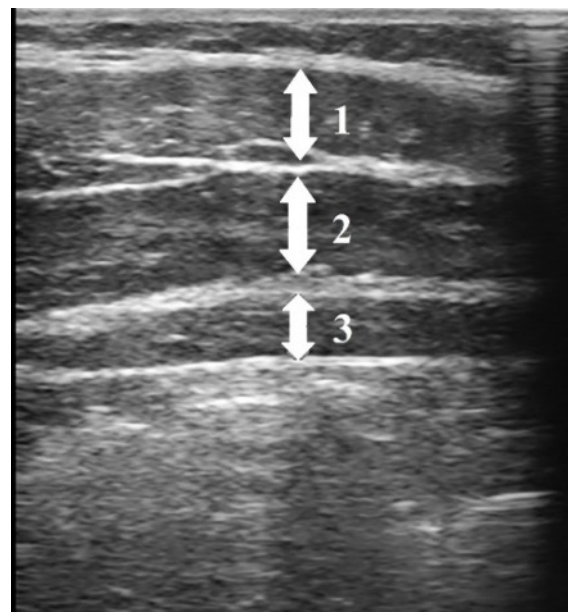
Ultrasound image of the lateral abdominal wall muscles. Determination of the cross-section: 1 – external oblique, 2 – internal oblique, 3 – transverse abdominal (own material)
